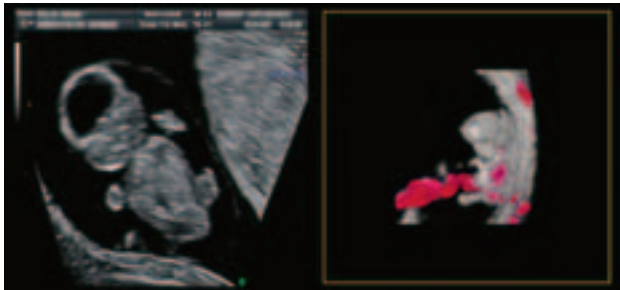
2D and 3D power Doppler image of nine weeks old fetus. Blood flow through umbilical cord and fetal heart is visualised.
